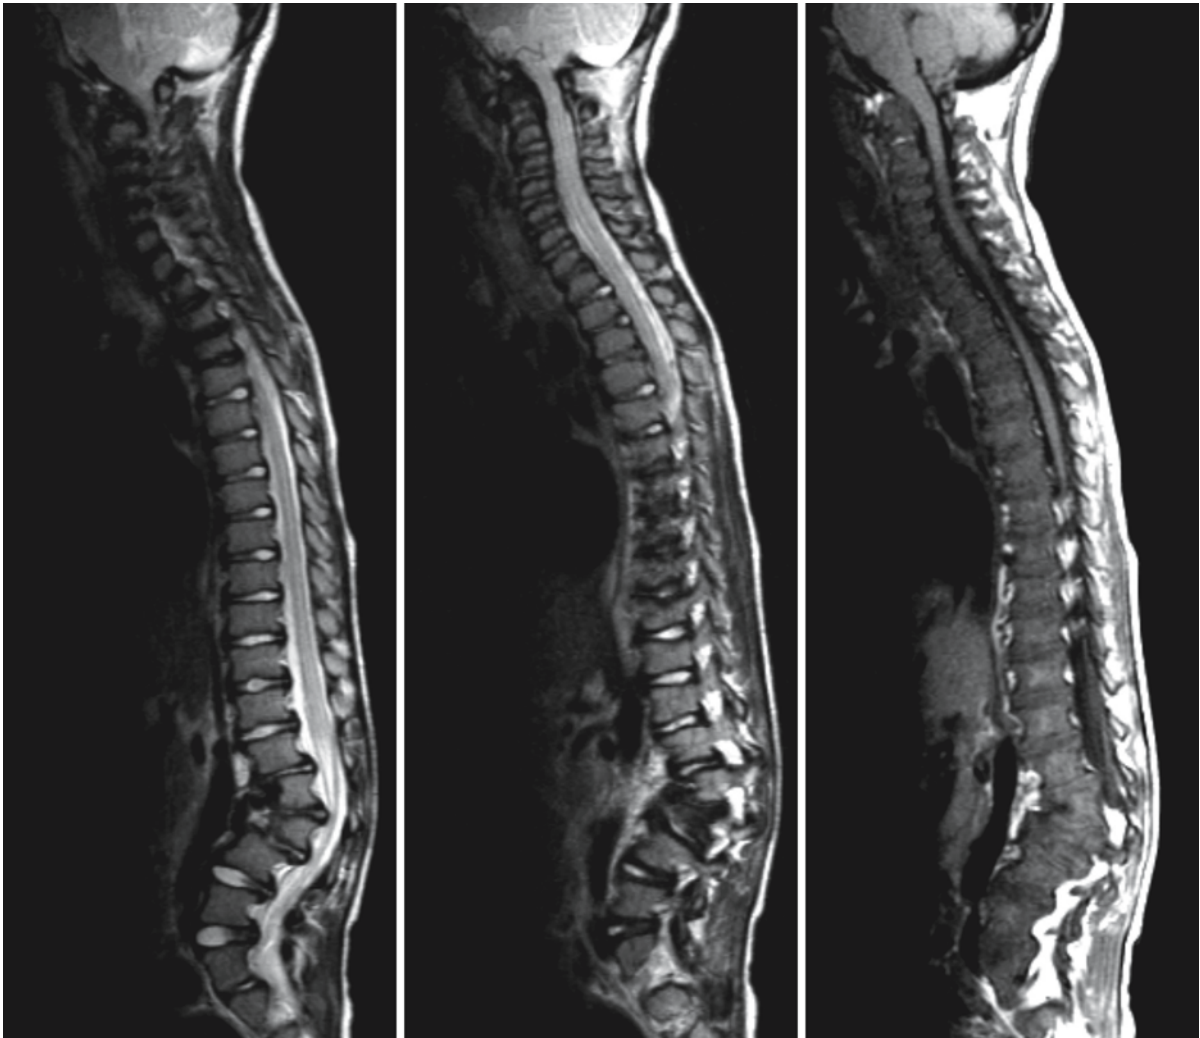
Spinal MRI of a 5-year-old boy with Maroteaux–Lamy syndrome (MPS VI) shows abnormalities of the craniocervical junction, with deposits of mucopolysaccharide material around the dens, narrowing the spinal canal. The T₂-weighted images show no free CSF space around the cervical
